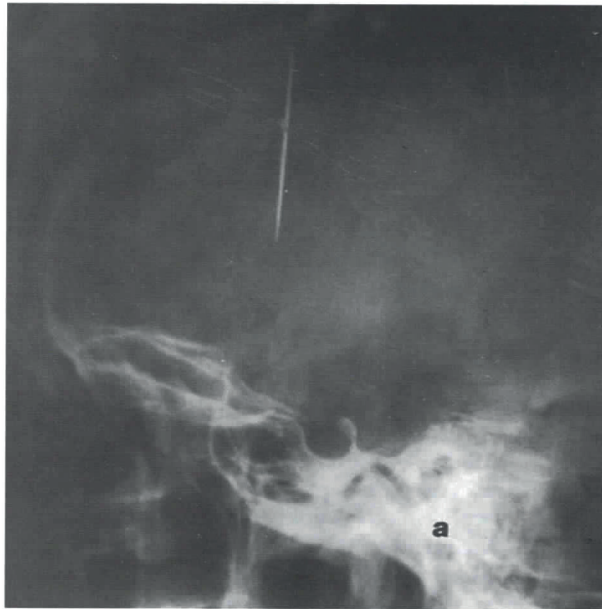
Plain skull radiographs showed a sewing needle in the posterior frontal region at the midline. Lateral (a), and anteroposterior (b) view of the cranium.
